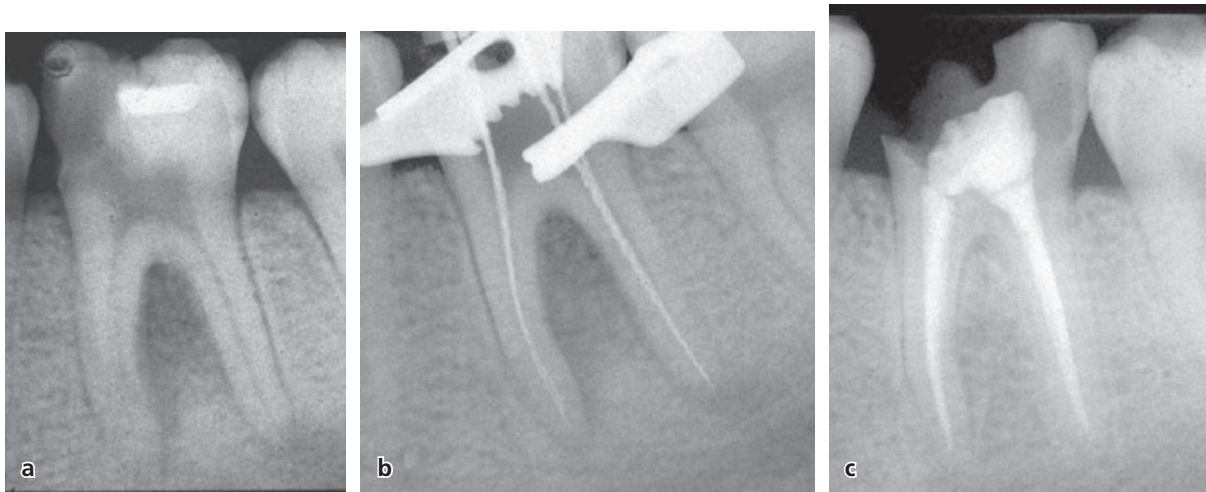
(a) A large radiolucent area is present in the furcal region of a lower left first molar mimicking a furcation involvement caused by periodontal disease. In this case the lesion was of endodontic origin as indicated by the large caries lesion and necrosis of the pulp. (b) Endodontic treatment resulted in complete resolution of the bone lesion as demonstrated by the 18-month follow-up radiograph (c). Case kindly provided by Dr. Kevin Martin.
